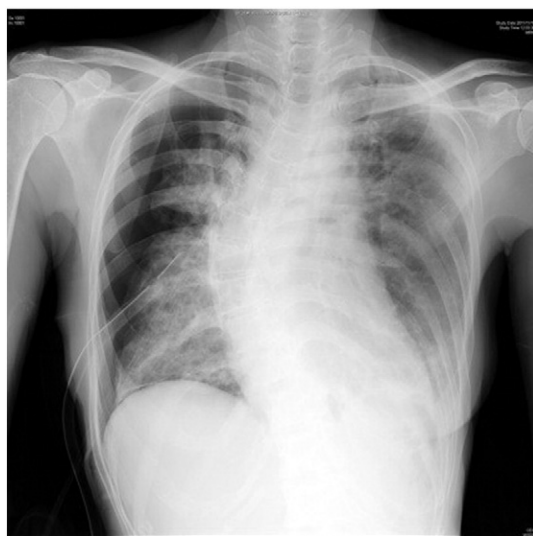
Preoperative chest x-ray shows diffuse reticulonodular shadows in both lower lung fields and significant scoliosis. Pneumothorax was not improved by pleural cavity drainage.
